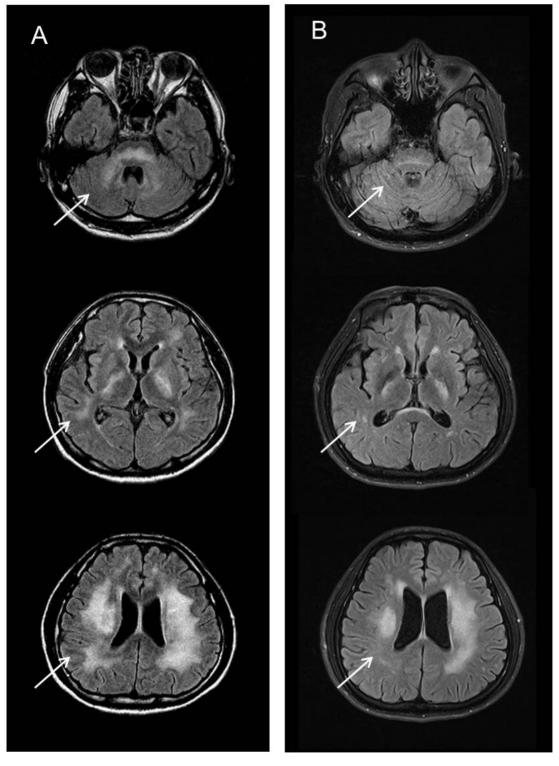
Brain MRI of the patient before and 5 months after initiation of HAART. (A) The brain MRI before HAART showed confluent white matter lesions with increased T2 signal involving the subcortical to periventricular area and pontocerebellar tract (arrows). (B) Follow-up brain MRI 5 months after the initiation of HAART showed significantly reduced white matter lesions in the subcortical deep white matter and pontocerebellar tracts (arrows).
